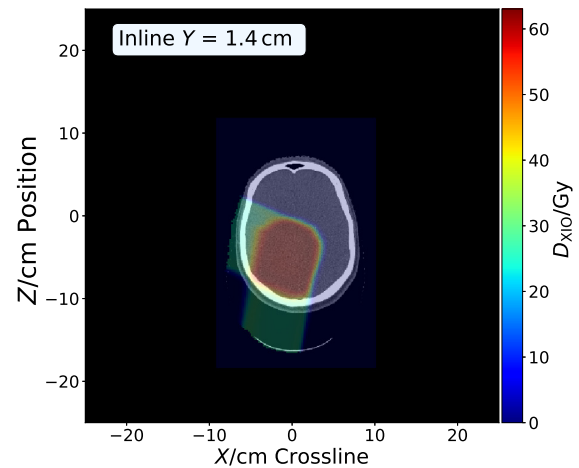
One CT image slice and the corresponding planned dose image which belongs to Patient 1. The planned dose is generated by the treatment planning system XIO..
